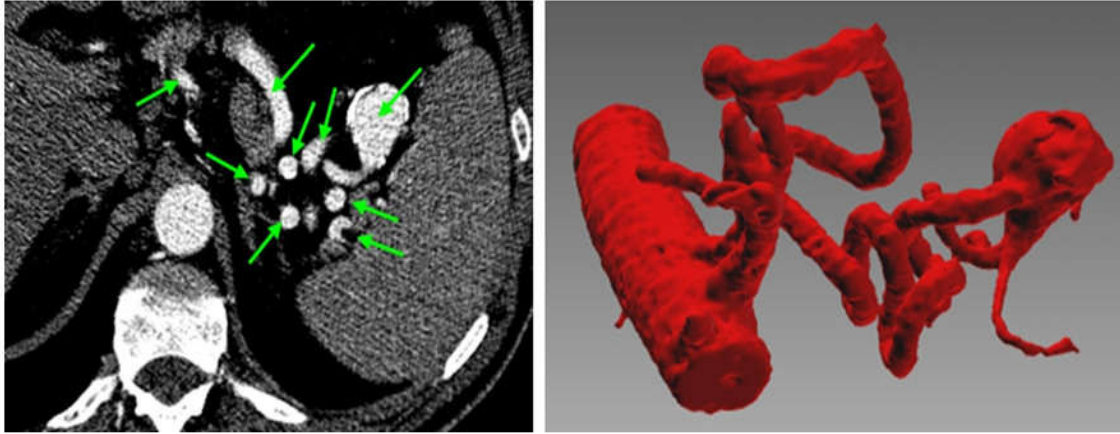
(left) Traditionally 2D visualization in a CT slice of a splenic artery indicated with the arrows. (right) Corresponding 3D model.
